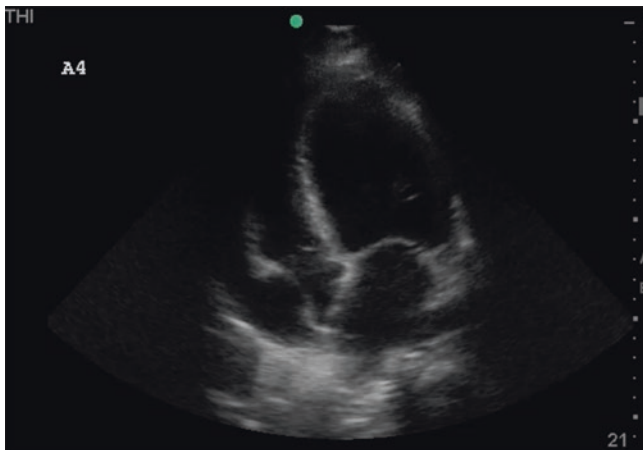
Ultrasound findings
